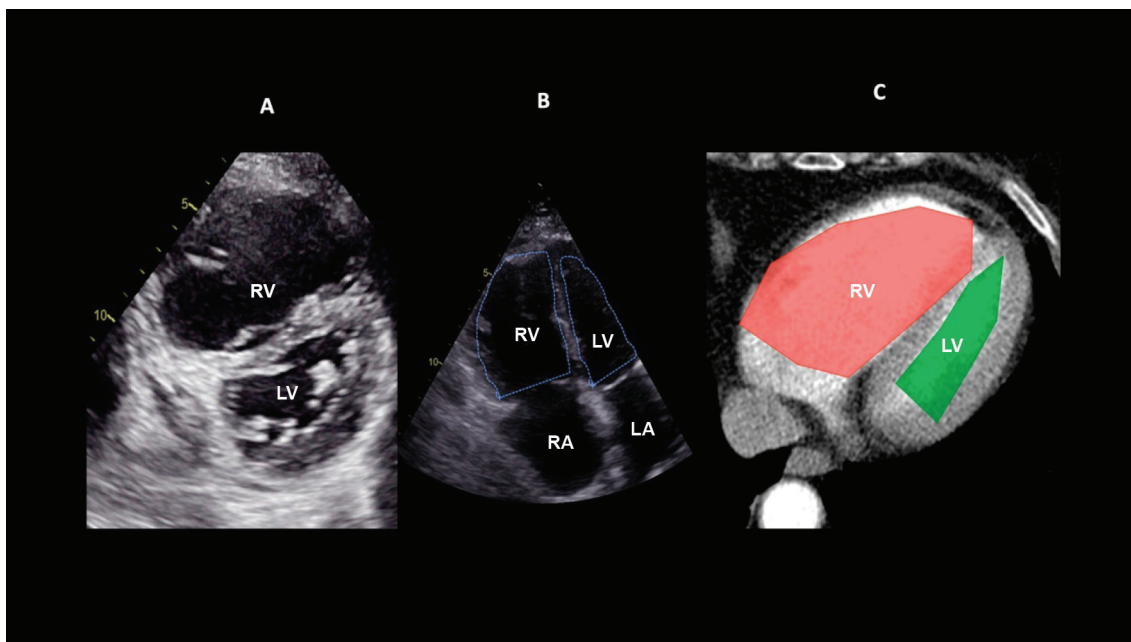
Right ventricular (RV) pressure overload and/or dysfunction A: straightening of the interventricular septum with RV dilatation in the parasternal cross-sectional view; B: RV dilatation assessed in the apical view by the RV:LV ratio at end-diastole (>0.6 mild; 1-2 important; >2 severe); C: equivalent to RV:LV ratio assessed by CT angiography. RV: right ventricle; LV: left ventricle; RA: right atrium; LA: left atrium.
